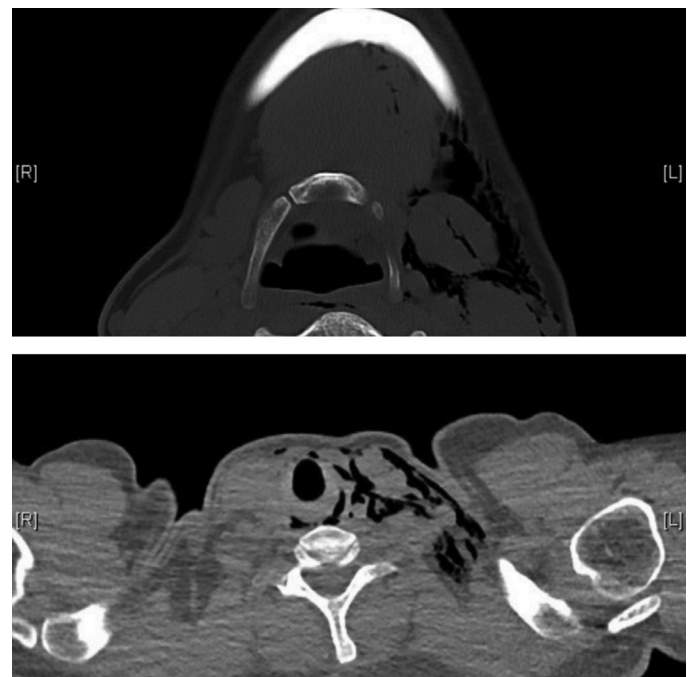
Above: CT image of cervicofacial emphysema below: pneumomediastinum on chest CT
